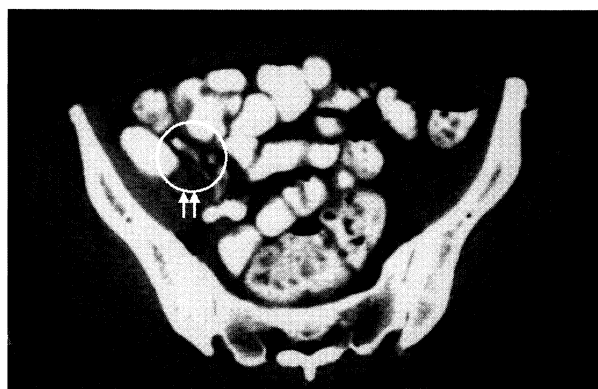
CT scan in patient (42years old, female, WBC: 11100, CRP:2.2) with normal appendix. CT scan at the cecal level displays a contrast material-filled normal appendix without appendiceal wall thickness.
